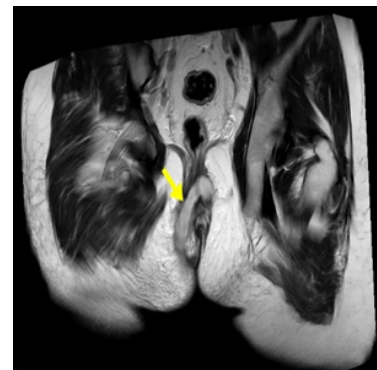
MRI T2 coronal oblique image shows a large sinus tract crossing the midline.
